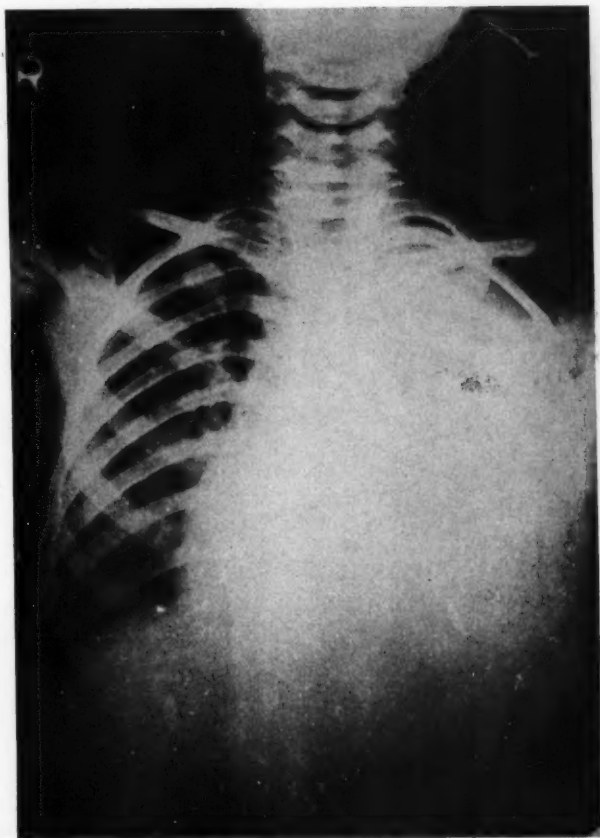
Third hospital day. X-ray reveals a massive left pleural effusion.
